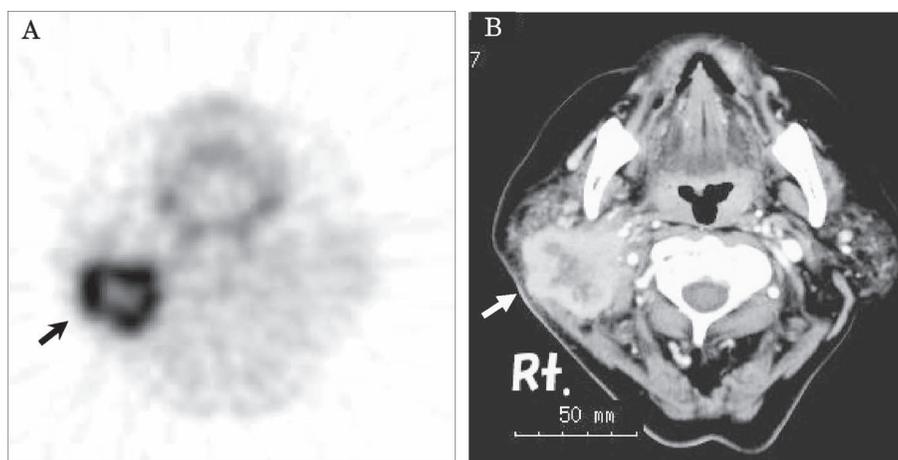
PET image using  $^{18}\text{F}$ - $^{10}\text{B}$ -parabononophenylalanine (BPA) in a patient with a right parotid cancer.  $^{18}\text{F}$ - $^{10}\text{B}$ -BPA PET clearly visualized the submandibular tumor (arrow) with a tumor-to-contralateral normal tissue ratio of 5.0. A: PET image, B: contrast-enhanced CT (Courtesy of Prof. Jun-ichi Hiratsuka).
